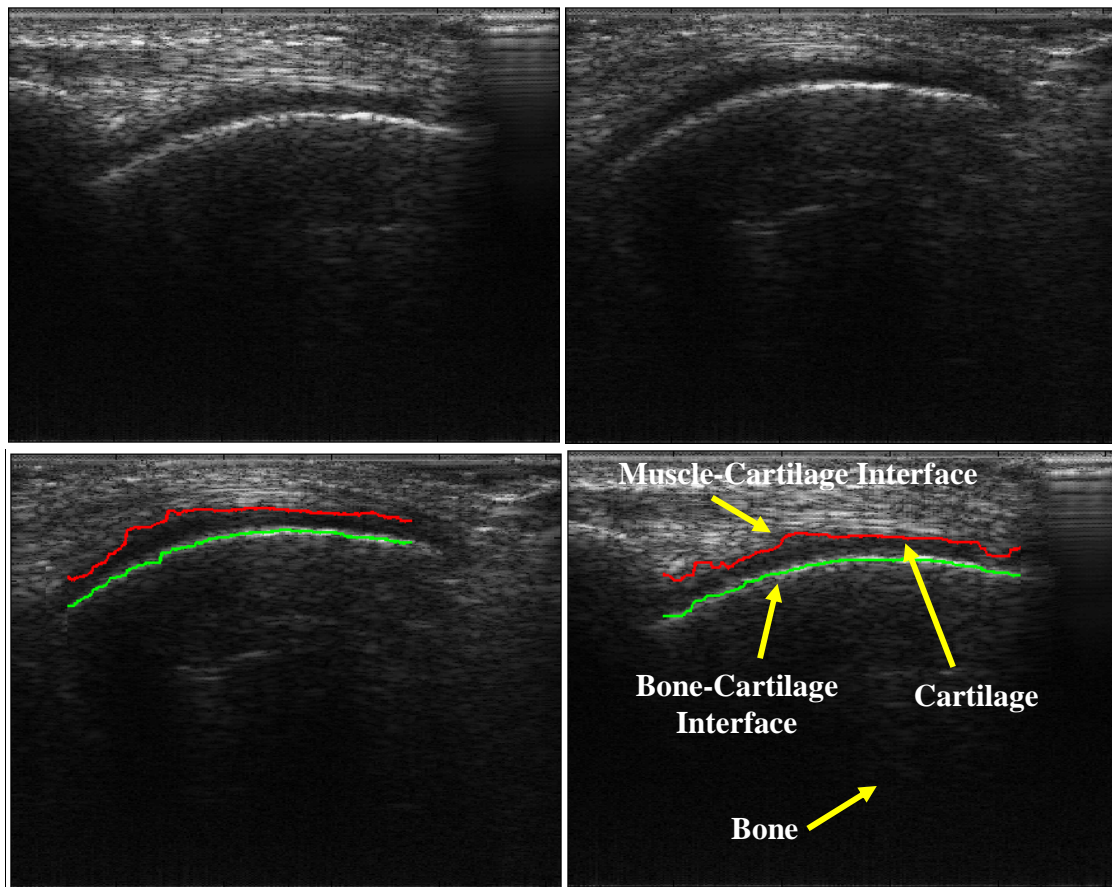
Two examples for bone (in green) and cartilage (red) contours extracted using the ultrasound RF data overlaid on their B-mode images, for two frames of one of the clinical study volunteers' femoral condyle scans. The cartilage is the hypo echoic region lying between the bone and cartilage contours.
